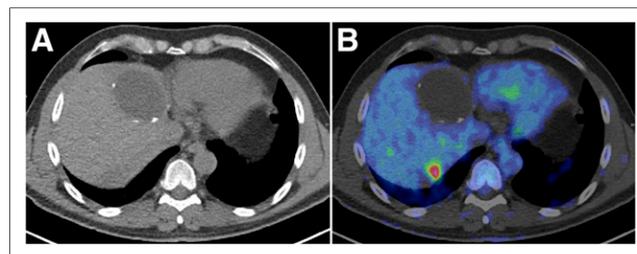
CT (A) and PET/CT (B) show ill-defined, hypodense region of hepatic segment 7, representing anatomically stable ablation bed of previously treated lesion. Fused image reveals metabolically active tumor along ablation bed. Anterior hypodense, metabolically quiescent lesion represents chronic asymptomatic biloma.
